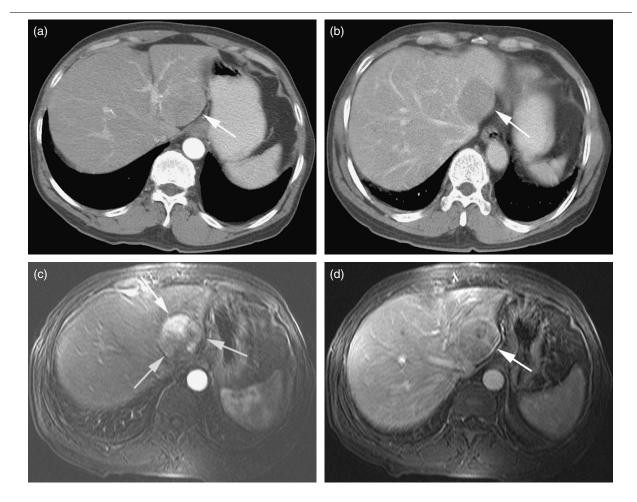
HCC. (a) Arterial phase helical CT shows a minimally hyperdense lesion (arrow). (b) Portal venous phase helical CT shows that the lesion has faded and an enhancing pseudocapsule is noted (arrow). (c) Arterial phase T1-weighted fat-suppressed 3D gradient-echo scan shows enhancement of the lesion better than CT. Note that the lesion is predominantly composed of three lesions enhancing to different degrees (arrows), 'tiled' together like a 'mosaic'. Note that MR shows the mosaic pattern of HCC better than CT. (d) Portal venous phase T1-weighted fat-suppressed 3D gradient-echo scan shows that there is an enhancing pseudocapsule encircling the mosaic of 'tiles' and the confluent portions of each nodule form a triangularly shaped enhancing fibrous septa (arrow). Note that MR shows the pseudocapsule and fibrous septa better than CT. (Reproduced with permissions from Thng CH, Kuo Y, Blomley MJ. Imaging hepatocellular carcinoma. Cancer Rev Asia-Pacific 2003; 1: 191.)
